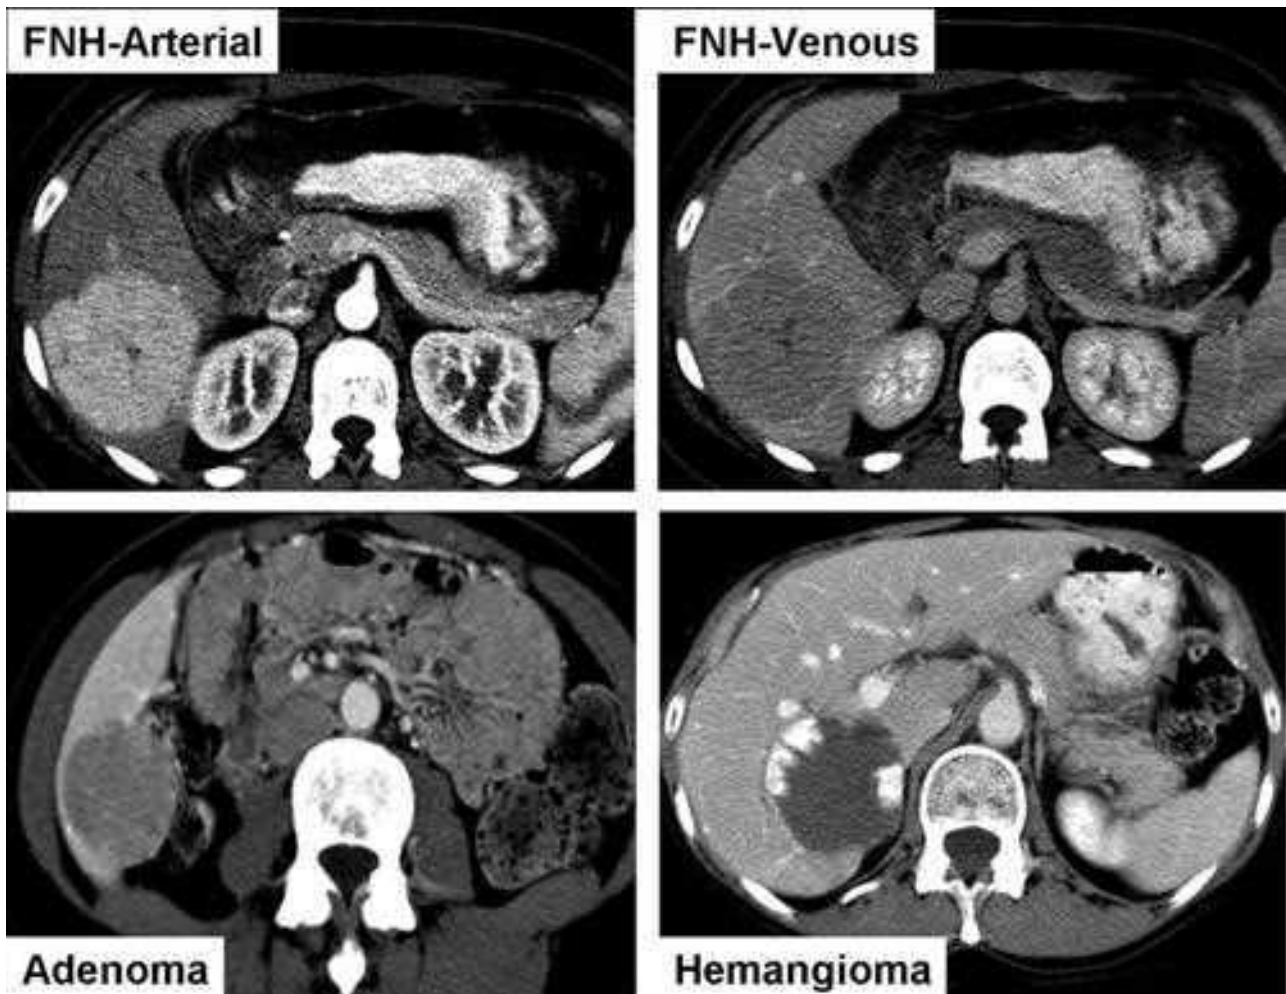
Computed tomographic scans showing classic appearance of benign liver lesions. Focal nodular hyperplasia (FNH) is hypervascular on arterial phase, isodense to liver on venous phase, and has a central scar (*upper panels*). Adenoma is hypovascular (*lower left panel*). Hemangioma shows asymmetrical peripheral enhancement (*lower right panel*).
